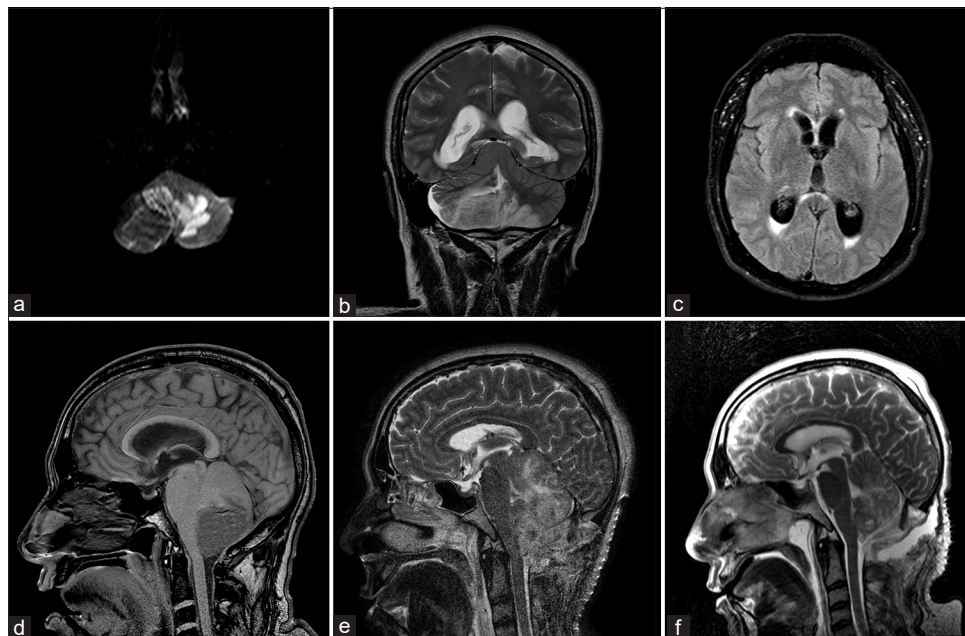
PICA infarct with hemorrhagic transformation involving the posterior lobe of both cerebellar hemispheres seen on DWI (a), T2 (b) and the associated obstructive non-communicating hydrocephalus (c, d). After the EVD and the suboccipital craniectomy, the patient persisted with upward transtentorial herniation (e); notice the flattening of the quadrigeminal cistern, the “spinning top” appearance of the midbrain and the cerebral aqueduct occlusion. After the ETV, the upward transtentorial herniation was reversed (f) and the patient improved clinically.
